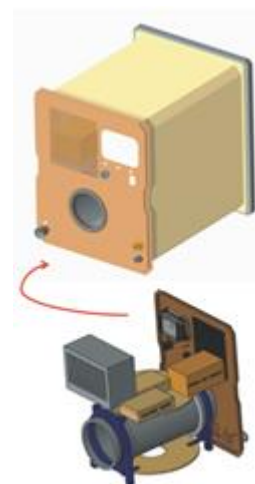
The space MRI can image a wrist or ankle with low power needs and could fit into a mid-locker of an express rack (University of Saskatchewan, 2021).
